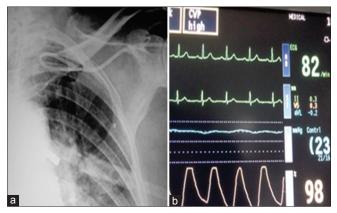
(a) Monitor showing dampened/absent CVP waveform with abnormal value. (b) Chest X-ray PA view with C-coiled CVP catheter *in situ*
